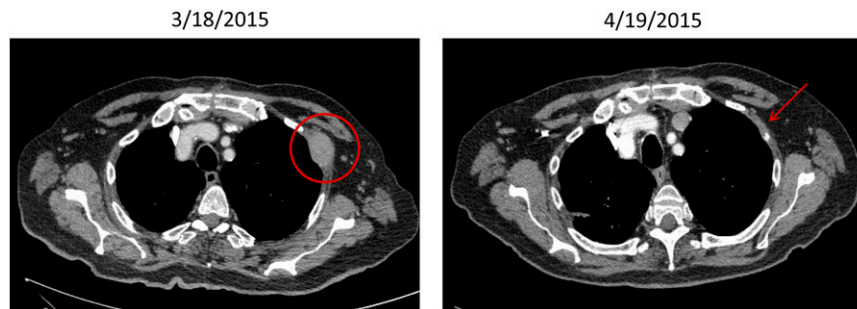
Computed tomographic scans obtained after 4 weeks of crizotinib treatment in a 73-year-old man with metastatic squamous cell lung cancer and MET exon 14 skipping.
